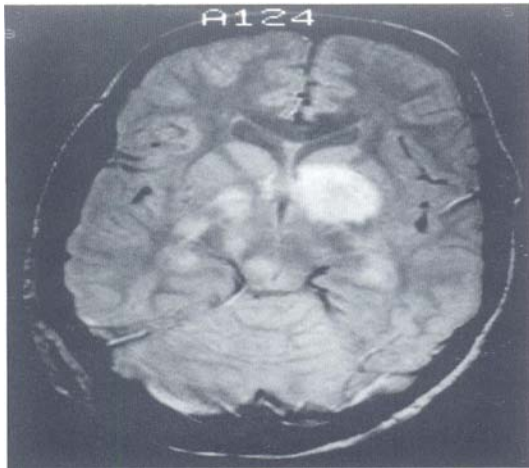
Axial MRI Proton density: multiple hamartomas in neurofibromatosis type 1
